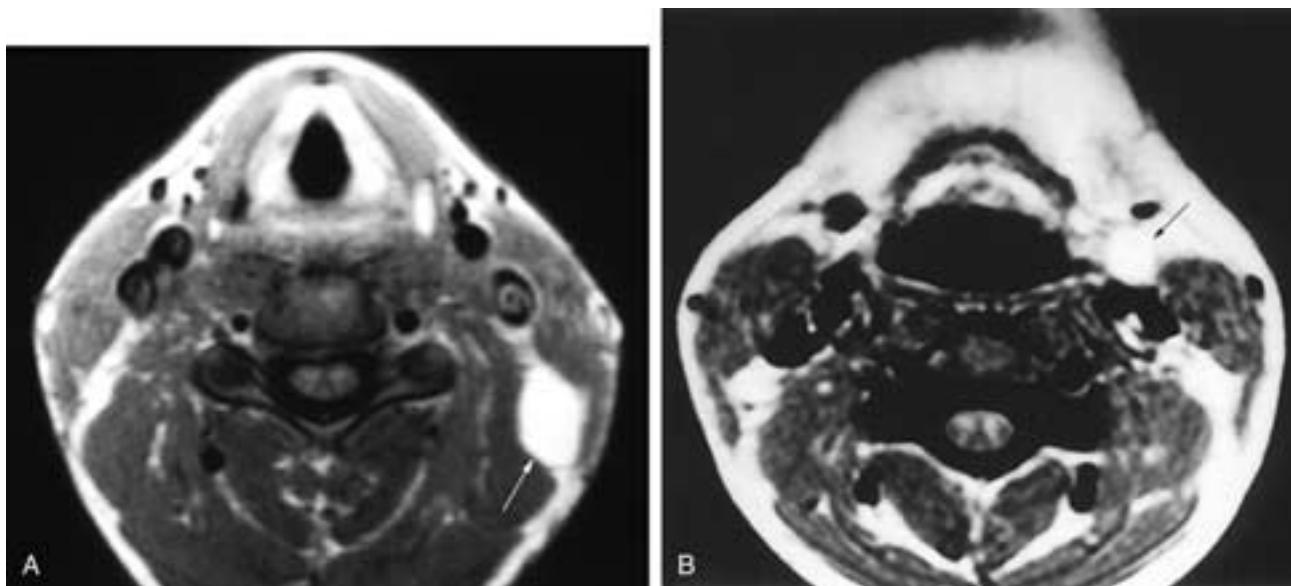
Axial T1-weighted MR images on two different patients. In A, there is a left level II node with high signal intensity (*arrow*) deep to the sternocleidomastoid muscle. In B, there is a left level II node with high signal intensity (*arrow*) adjacent to the carotid artery. Both of these nodes contained metastatic papillary thyroid carcinoma.
